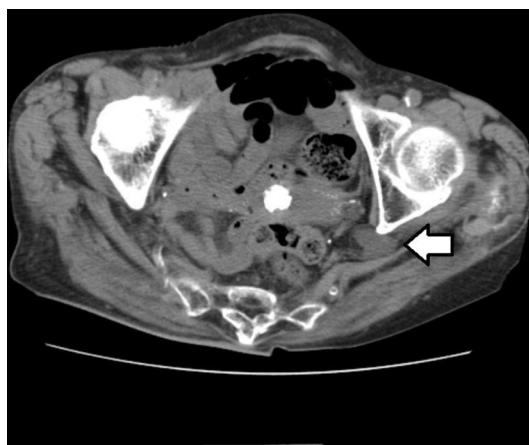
Abdominal CT showed a left distal ureter with herniation into the sciatic foramen. (arrow).
